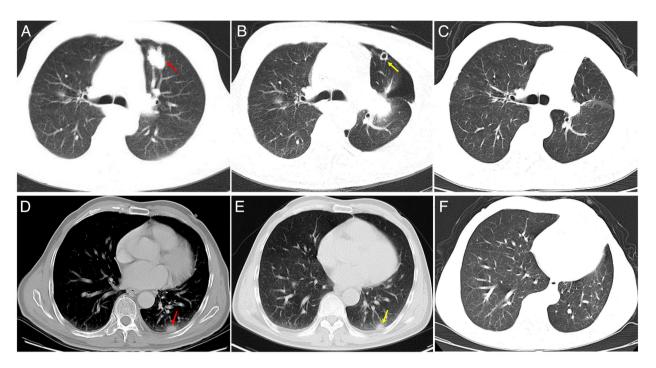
Chest images. (A) Chest CT scan showing a 2.4x2.0-cm nodule in the anterior segment of the left superior lobe (red arrow) and peripheral lung cancer was highly suspected. (B) Chest CT scan showing a thoracic tube (yellow arrow) after surgical resection of a nodule in the anterior segment of the left upper lobe, which was diagnosed as adenocarcinoma. (C) Chest CT scan indicating no recurrence of lung cancer during the 5 years after surgery. (D) Chest CT scan showing a 1.3x0.9-cm nodule in the posterior basal segment of the left lower lobe (red arrow) and intrapulmonary metastasis was suspected. (E) Chest CT scan indicating that the posterior basal segment nodule of the left lower lobe with the diagnosis of PC (yellow arrow) was reduced in size after one month of antifungal treatment. (F) Chest CT scan showing that the PC nodule in the posterior basal segment of the left inferior lobe had disappeared after 6 months of antifungal therapy during the 5-year follow-up. PC, pulmonary cryptococcus; CT, computed tomography.
